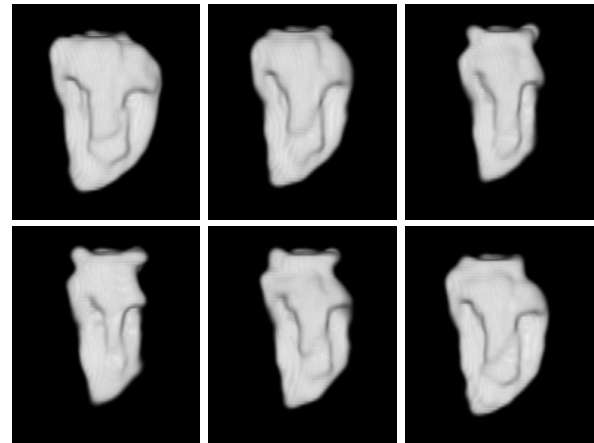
4D segmentation and interpolation of the LV cavity from a cardiac MRI: 6 different time frames.
